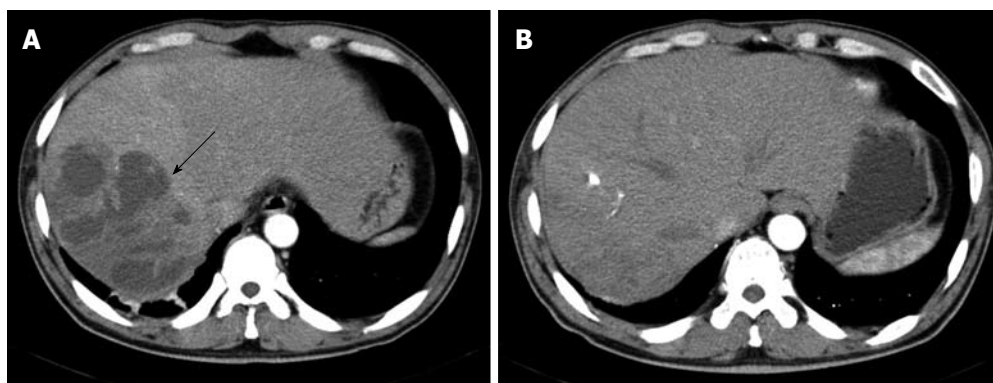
Contrast-enhanced computed tomography (CT) of the liver. A: Abdominal CT scan showing a multi-loculated liver abscess (12 cm × 9 cm) in the posterior inferior (VI segment) and posterior superior segment of the right lobe (VII segment) of the liver (arrow); B: On hospital day 30, the liver abscess was almost absorbed.
